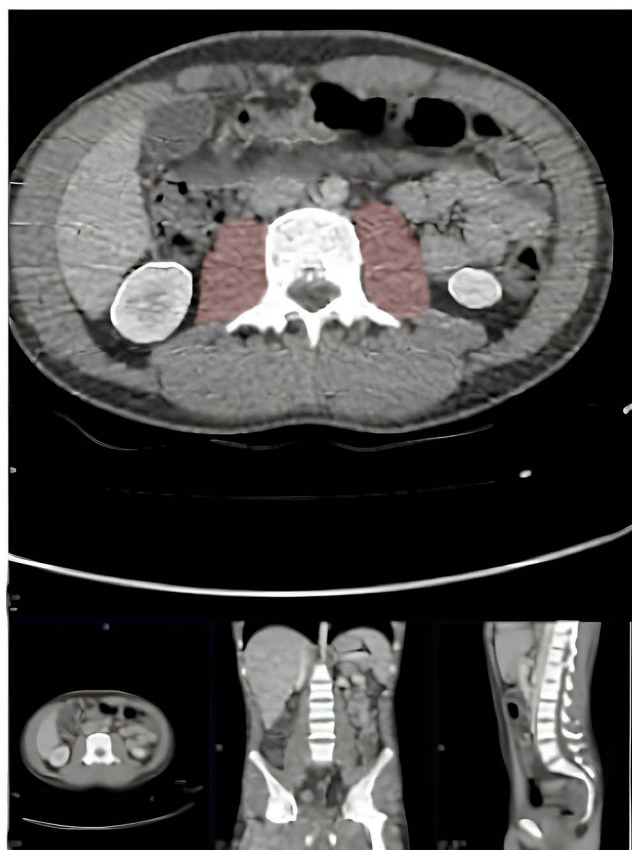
Axial L3 contrast-enhanced CT slice demonstrating manual segmentation of the bilateral psoas muscles at the level of the third lumbar vertebra (L3). The red outlined regions indicate the left and right psoas muscles; the sum of their cross-sectional areas is normalized to patient height squared (mm^2/m^2) to calculate the psoas muscle index (PMI).
